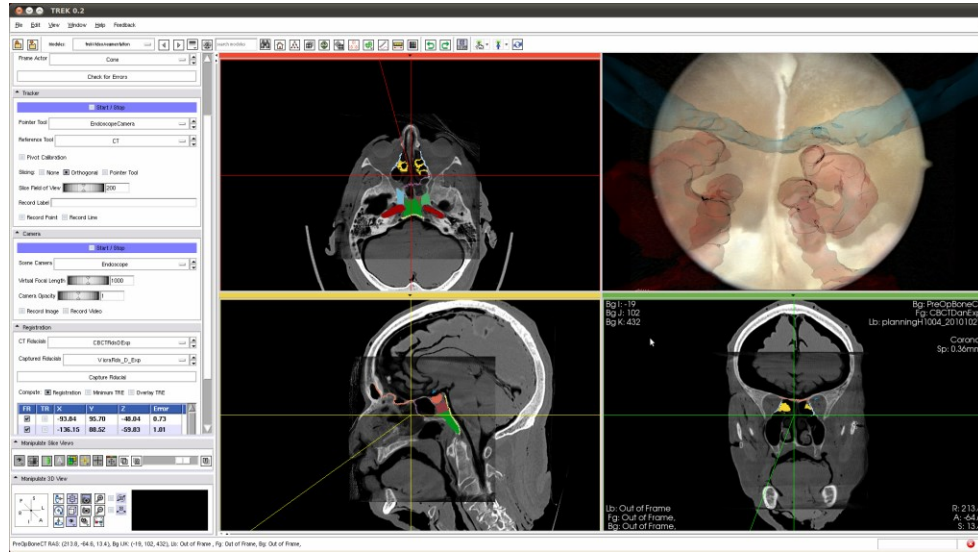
Screenshot of the video-CT system's interface including the augmented display and triplanar view of the CT and surgical plan.
